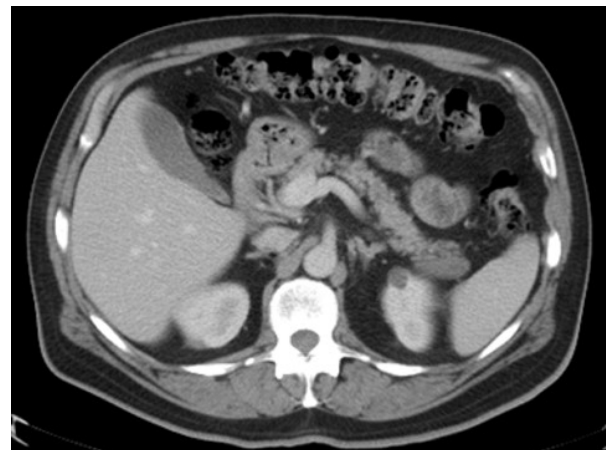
CT view of the lymphoepithelial cyst tumor at the level of the pancreatic tail.
